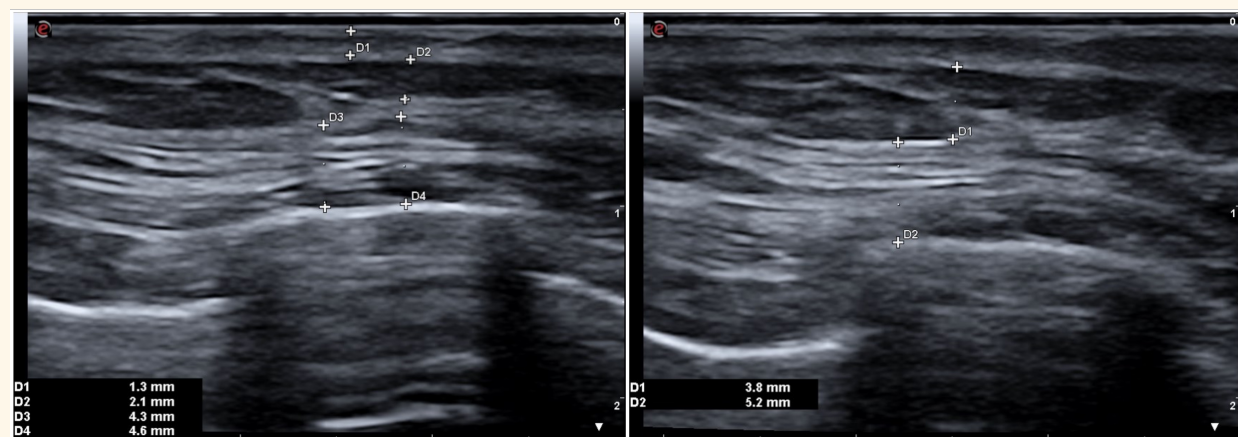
After three months follow-up, image of sonography confirmed improving subcutaneous edema and spasm of PM muscle.
